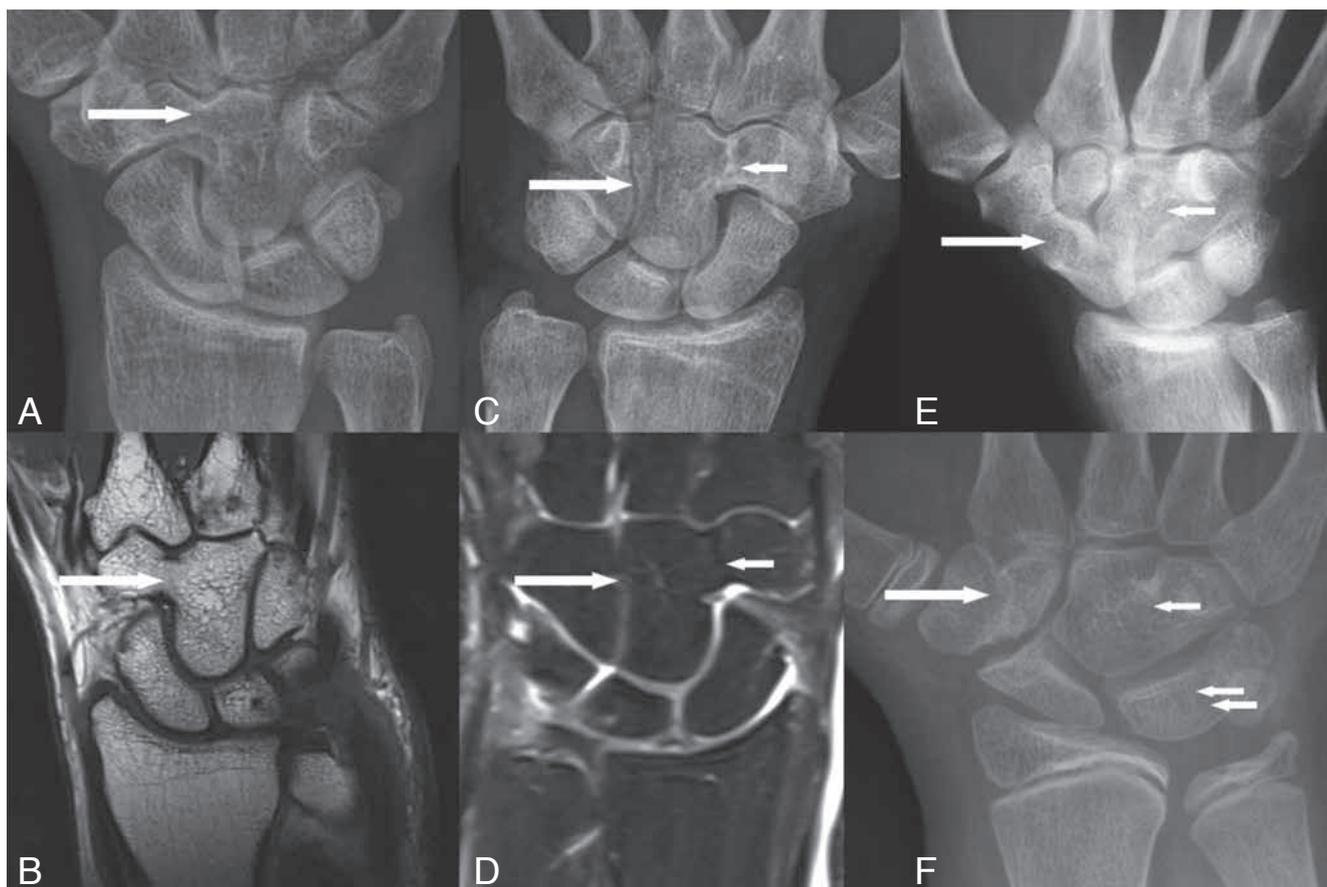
Isolated and combined coalitions. (A), (B), (C), (E) and (F) Plain radiography, (B) Coronal SE T1-WI and (D) Coronal SE T2-WI. A and B trapezoid-capitate coalition (arrows), C, and D capitate-hamate (long arrows) and trapezoid-capitate (short arrows). E. scapho-trapezium (long arrow) and capitate-hamate (short arrow). F. trapezo-trapezoid (long arrow), capitate-hamate (short arrow) and LTC (double short arrow).
